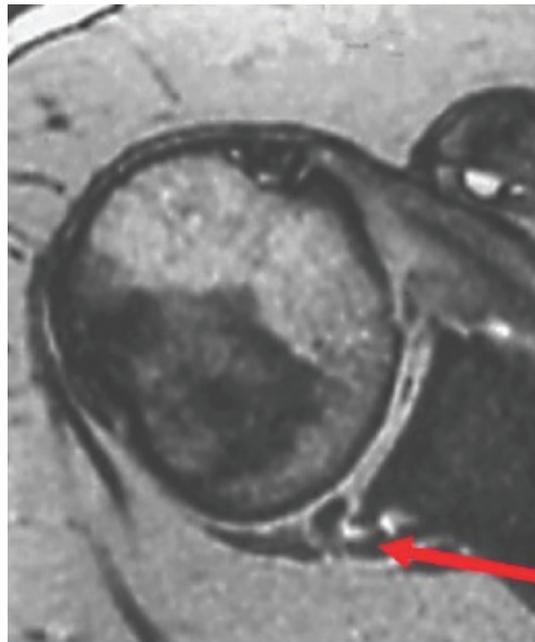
Magnetic resonance imaging (MRI) with gadolinium contrast dye reveals a SLAP tear. However, clinical evaluation is critical to confirm the diagnosis as a cause of pain.
